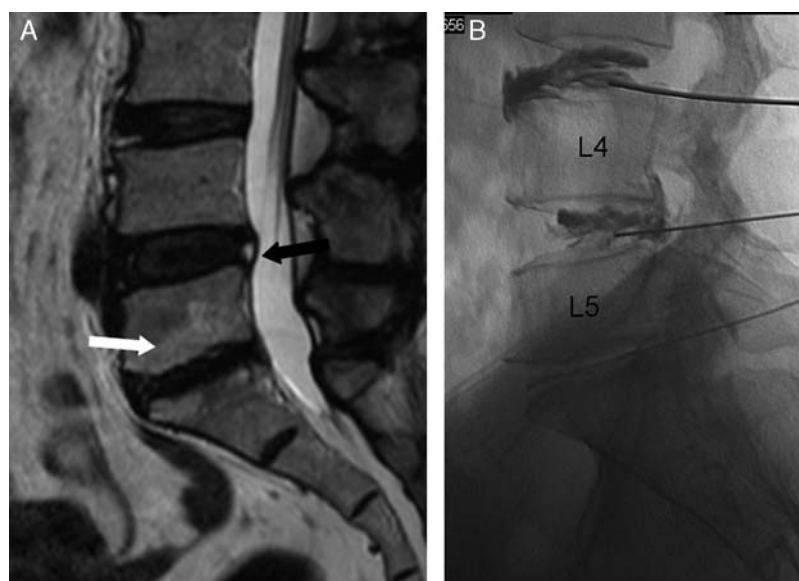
A 45-year-old woman had suffered from chronic LBP for 36 months. Sagittal (A) T2-weighted MR images showed grade V degeneration at the L3-to-S1 intervertebral disk levels. The L4-to-L5 intervertebral disk levels had a HIZ (black arrow), the L5-to-S1 intervertebral disk level with endplate abnormalities (white arrow). B, Lateral discography showed a rupture of anterior annulus fibrosis at L3-to-L4 intervertebral disk level, the patient had discordant pain during discography. A posterior annulus fibrosis was shown at L4-to-L5 intervertebral disk level; the patient had concordant pain during discography. We did not find a ruptured disk at L5-to-S1 levels, but the patient had intense concordant pain during discography.
